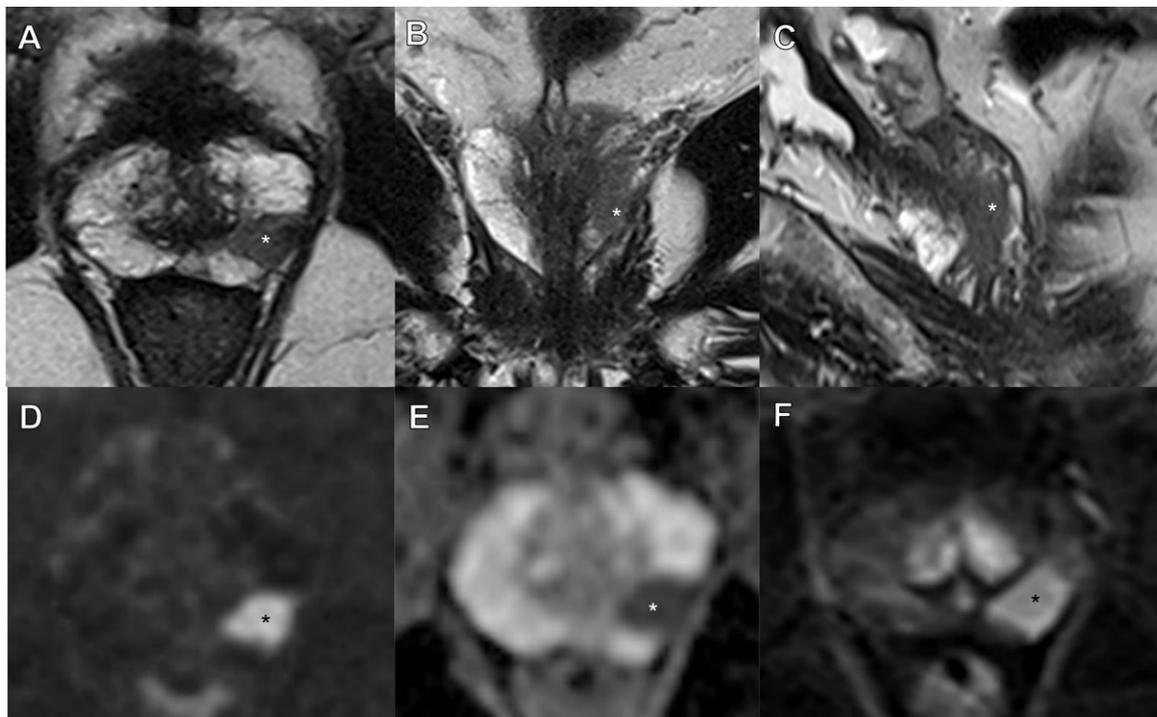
A case of multiparametric MRI of the prostate scoring Prostate Imaging Quality 5 (optimal diagnostic quality) in phase I. The lesion (*) in the left peripheral zone at midgland is clearly visible on axial (A), coronal (B), and sagittal (C) T2-weighted images as well as on a high-b-value image (D), an apparent diffusion coefficient map (E), and a dynamic contrast-enhanced image (F). The scan was fully compliant with the technical parameters described in Prostate Imaging Reporting and Data System, version 2.1, guidelines and the Prostate Imaging Quality visual assessment criteria for each sequence.
